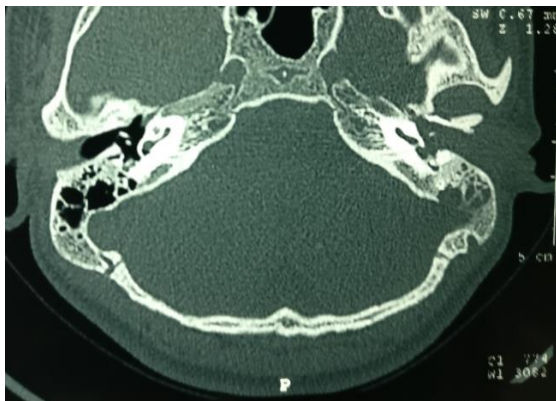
HRCT temporal bone Axial scan showing left ear ossicular erosion with soft tissue attenuation in middle and external ear.
